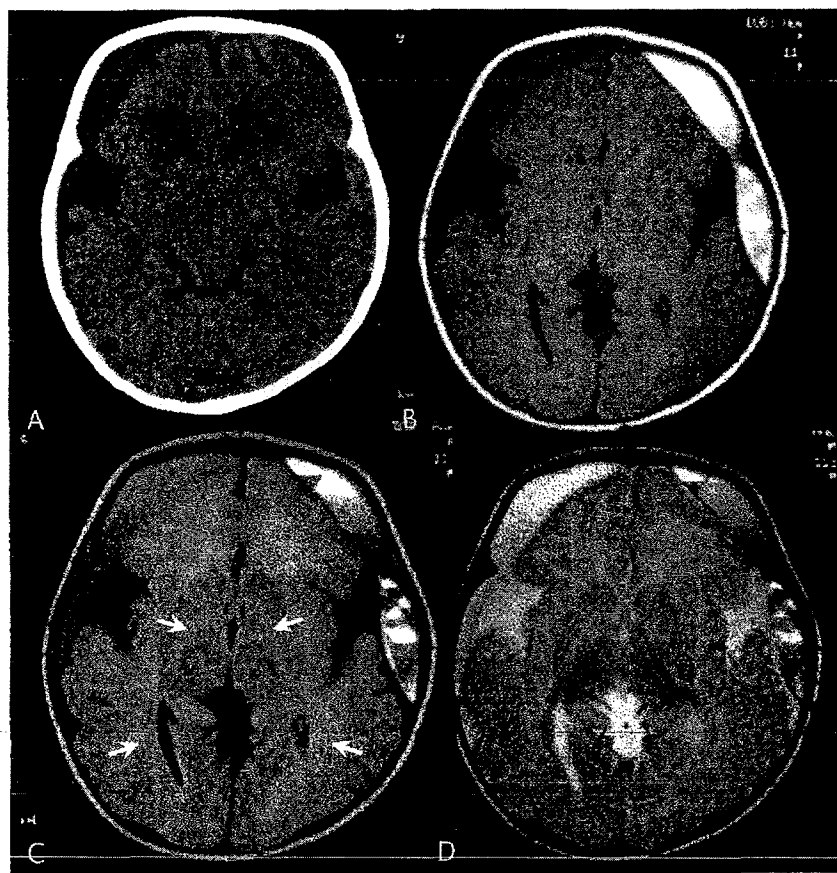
Images obtained from a 9-month-old male infant with glutaric aciduria type 1, SDHs, and RHs. CT (A), T1 (B), FLAIR (C), and T2 (D) MRI images show bilateral mixed-density and mixed-intensity extracerebral collections with fluid levels and septations, especially on the left side. Other characteristic findings for glutaric aciduria type 1 include bilaterally wide sylvian fissures (arachnoid cysts) plus abnormal basal ganglia (globus pallidus) and cerebral white matter intensities (arrows).
